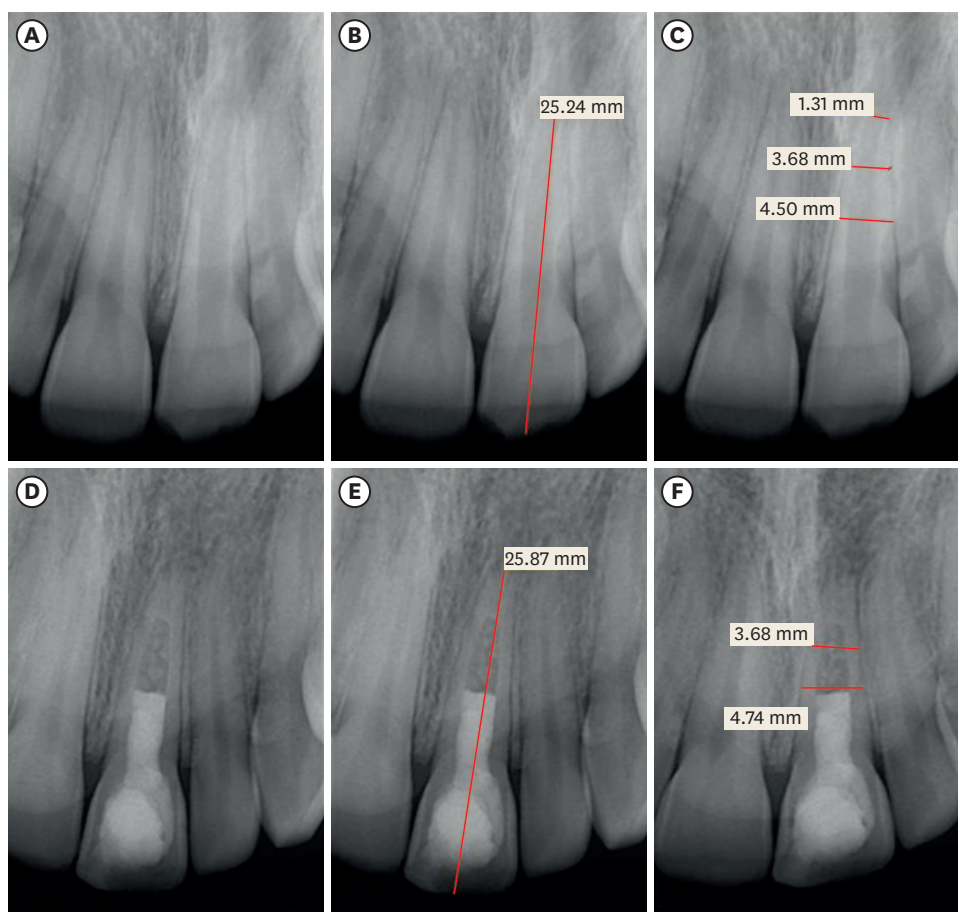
Maxillary left central incisor with open apex and apical radiolucency due to trauma (A-C). Calcium hydroxide was used as an intracanal medicament and the access was filled with mineral trioxide aggregate. 31-month postoperative radiographic follow-up shows complete apical closure, an increase in the tooth length, and healed (complete) apical radiolucency (D-F).
